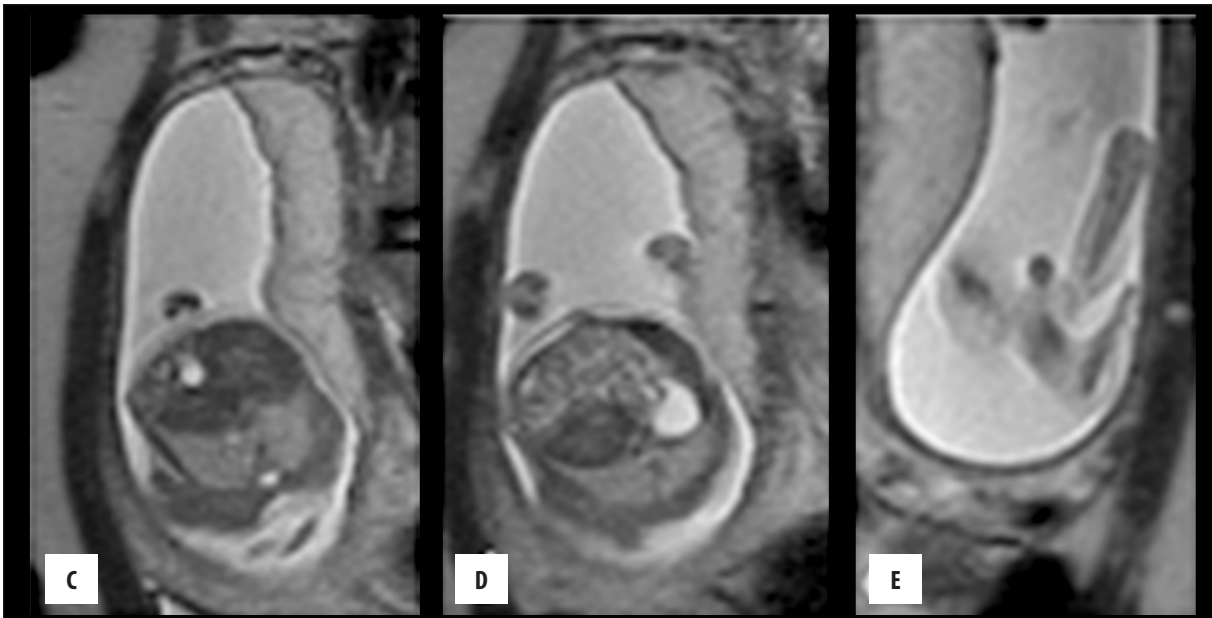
Foetal T2WI MRI (non-contrast images): (A, B) Sagittal sections of the foetus showing abrupt termination of the spinal cord and absence of the lumbosacral spine. (C, D) Axial sections of the foetal abdomen showing abrupt termination of the spine at the level of the stomach bubble. (E) Section of the foetal limbs showing clubbed feet.
